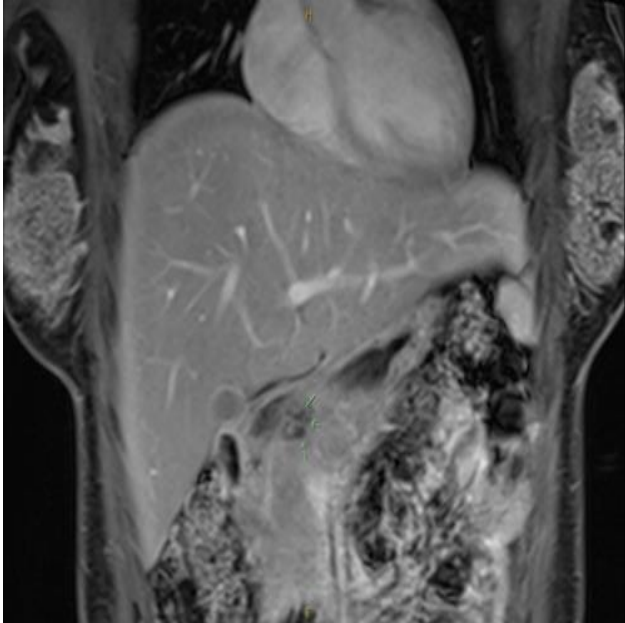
MRI abdomen coronal plane demonstrating head of pancreas lesion.
